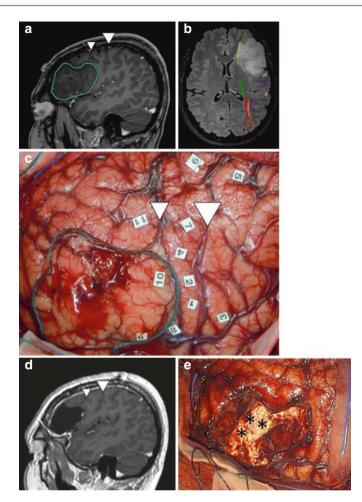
(a, b) MR images of a 29-year-old patient with a low-grade glioma in the left inferior frontal gyrus (this is a type of brain tumour that typically takes years to become symptomatic). Clinical debut was a seizure; there were no (neurological) deficits. The tumour had invaded classic Broca's area. The posterior border was the precentral sulcus (small arrow), and cranial border was the inferior frontal sulcus. The large arrow points to the central sulcus. Information from MR tractography in figure (b) is shown with colours. The yellow tract is the inferior fronto-occipital fasciculus (IFOF), which represents the medial functional border of the resection. (c) Intraoperative photograph before tumour resection. Contour of the tumour has been marked with a small cord. Small and large arrows indicate precentral and central sulcus, respectively. Numbered markers indicate sensorimotor and language areas that were found with electrocortical stimulation. Markers 1, 2, 4, 7, and 8 indicate the primary motor cortex. A speech arrest was found at markers 8 and 11. Stimulation at markers 9 and 10 did not yield consistent language errors, and these were not considered critical language areas. (d) Postoperative MR image demonstrated macroscopical complete resection. (e) Tumour resection was performed up to sulcal borders. Asterisk indicates sites where subcortical stimulation resulted in (semantic) language impairments, likely due to stimulation of the IFOF. The patient had transient speech disorders that became clinically manifest on the second day after surgery. Three months after surgery, these had resolved. Such a case demonstrates that the functional and anatomical localization of Broca's area do not necessarily coincide and strongly suggests that reorganization of function took place prior to-and possibly also after-surgery
